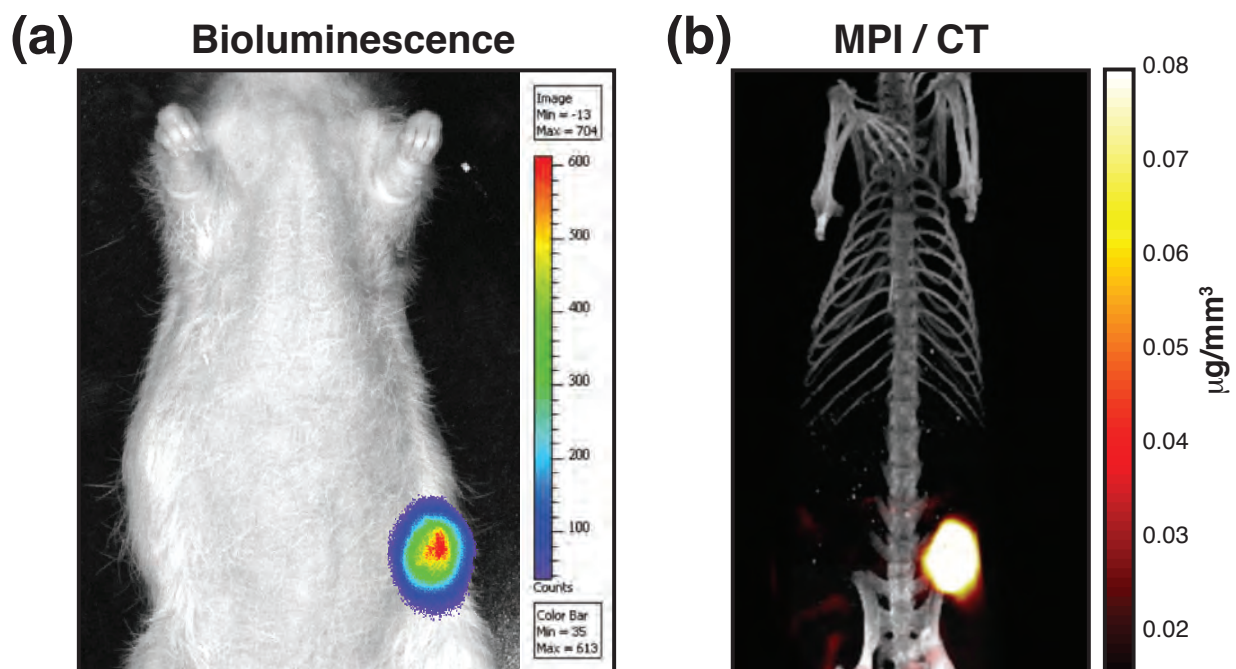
BLI and MPI/CT image of Xenograft Tumor. (a) Representative bioluminescence image of the MDA-MB-231-luc xenograft tumor. (b) Corresponding maximum intensity projection of the 3D MPI image (FOV: 40 mm  $\times$  40 mm  $\times$  58 mm) acquired 6 hours post injection with CT overlay.
